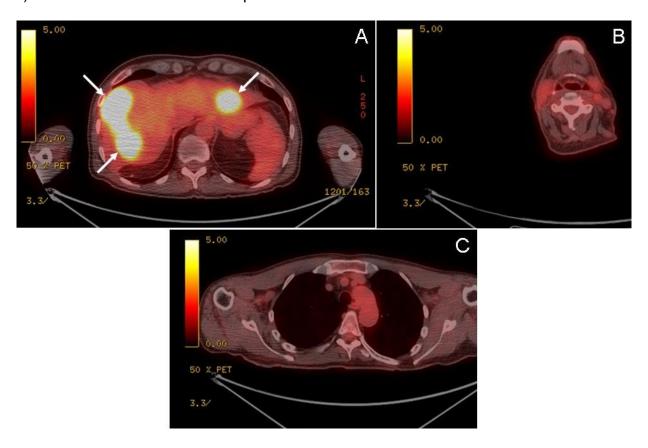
Panel A: Abdominal PET/CT scan showing increased uptake within the liver. Panel B: Neck PET/CT showing no increase in uptake. Panel C: Chest PET/CT showing no increased uptake.
